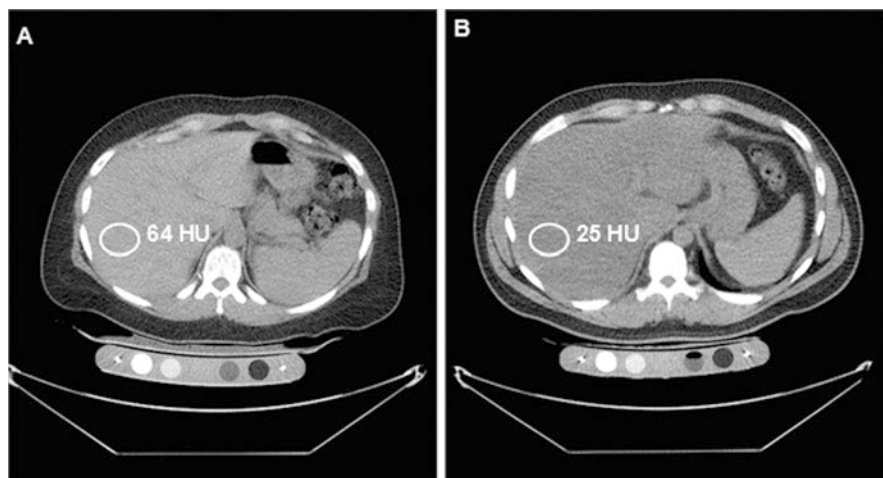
Non-contrast CT of the liver for assessment of intrahepatic lipid content in the right hepatic lobe in a 39-year-old woman with obesity (BMI, 31 kg/m²) (a) and a 37-year-old man with the same BMI (b). CT attenuation was lower in the man compared to the woman, consistent with fatty infiltration. Images are presented by using the same window and level
